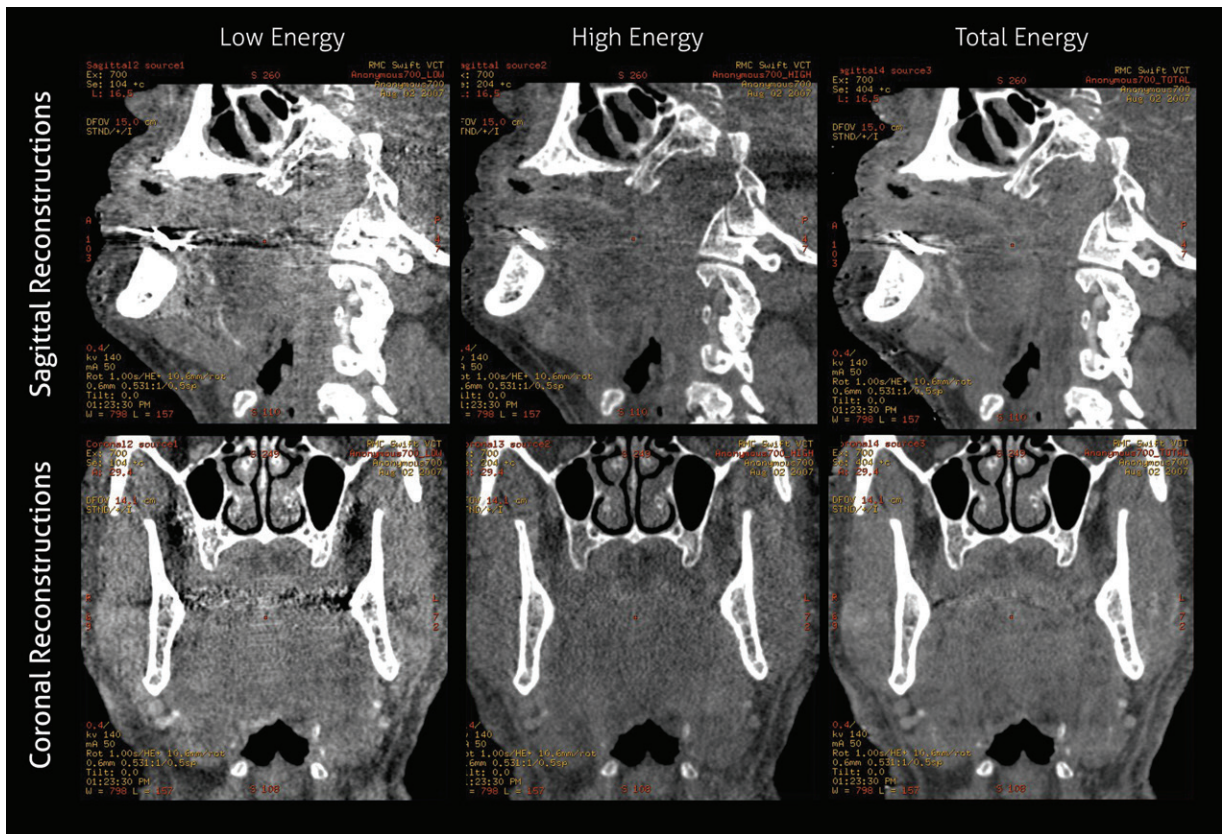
Images from first patient study with photon-counting CT, acquired with a prototype system (GE Healthcare, Chicago, Ill). Upper row shows sagittal images reconstructed at a low energy bin, high energy bin, and combined total energy, respectively. Lower row shows coronal images reconstructed at a low energy bin, high energy bin, and combined total energy, respectively. Note beam-hardening artifact reduction with the high energy bin. (Image courtesy of Ofer Benjaminov, MD, Rabin Medical Center, Israel, and Bob Senzig, MS, GE Healthcare.)
